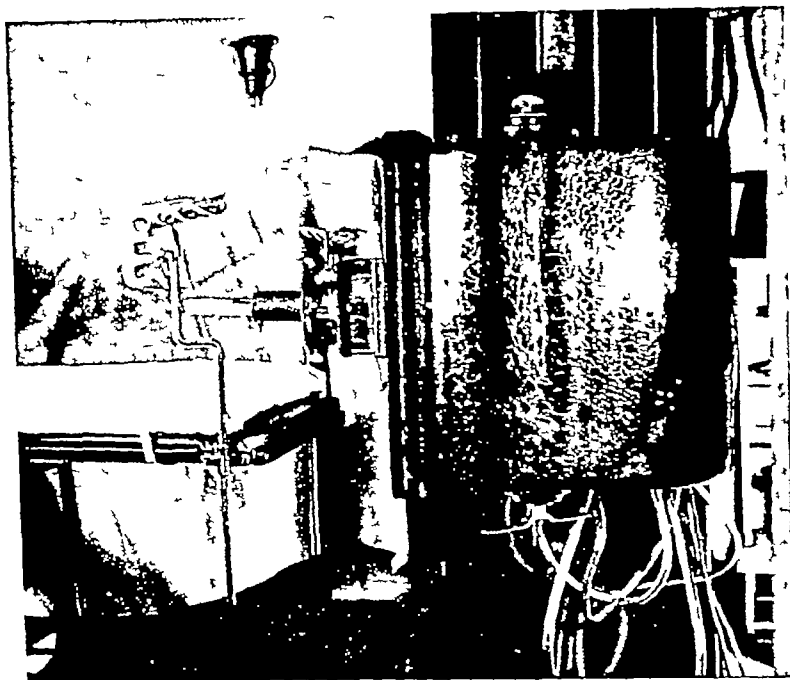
Apparatus for intravaginal roentgen therapy 200 kv
